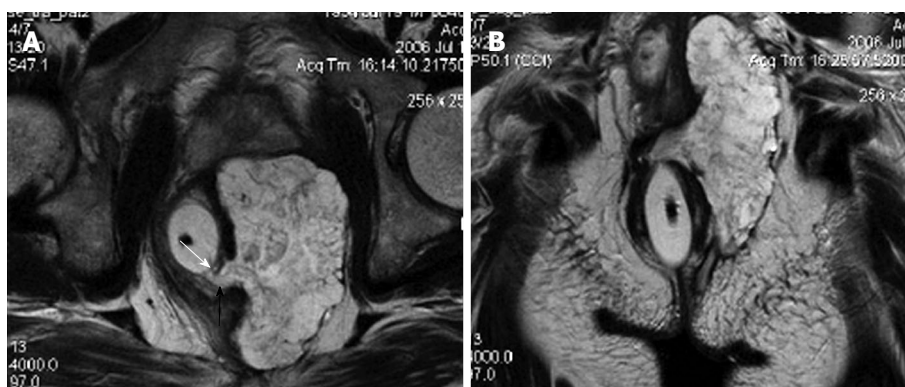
A 52-year-old man with mucinous adenocarcinoma caused by anal fistula. A, B: The mass displays heterogeneous intensity on T2-weighted magnetic resonance image. There is a fistula between the mass and the anus (black arrow) and an internal opening in anorectum (white arrow).
